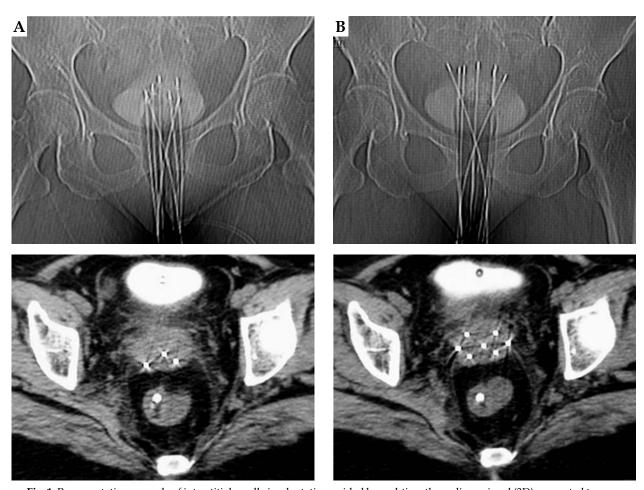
Representative example of interstitial needle implantation guided by real-time three-dimensional (3D) computed tomography (CT), for recurrent cervical cancer. Five interstitial metal needles were inserted by free-hand placement into the central tumor parallel to the vagina, and two interstitial metal needles were inserted into the distal extension at certain angles to the vagina at a depth of approximately 10 mm, as a preliminary implantation. The direction and depth of the seven needles was adjusted until satisfactory positioning was observed by multiple CT scans. A) Preliminary distribution of the needle position on the poster anterior radiograph (upper) and the axial CT image (lower) before adjustment (B). Final distribution of the needle position on the poster anterior radiograph (upper) and axial CT image (lower) after adjustment
